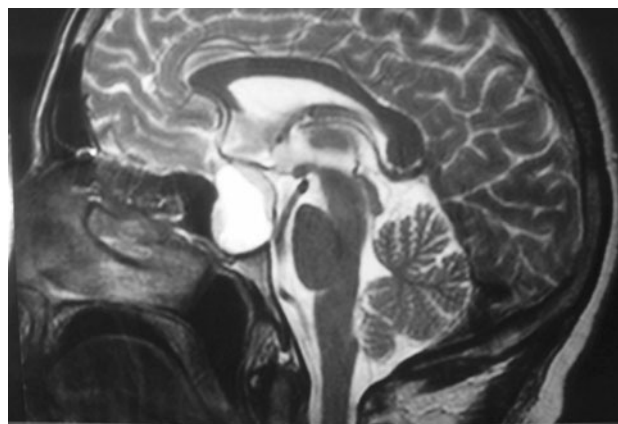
Sagittal MRI brain- showing pituitary tumour
